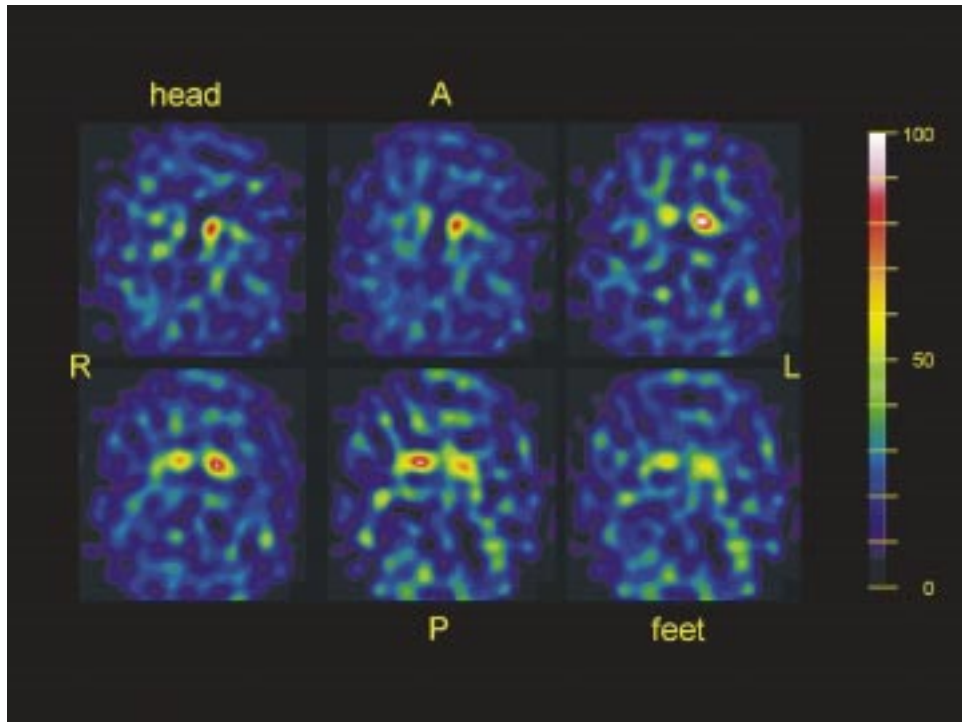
65-year-old patient with pronounced left-sided Parkinson symptoms for 8 years. The patient's symptoms started with marked tremor, and hypokinesia and dysbalance 3 years earlier. SPECT images were obtained 3 hours after the application of 200 MBq ^{123}I -FP-CIT. Note the bilateral loss of presynaptic dopamine transporter density in the putamen and a marked reduction in the right caudate nucleus, which is consistent with an advanced form of Parkinson's disease.
